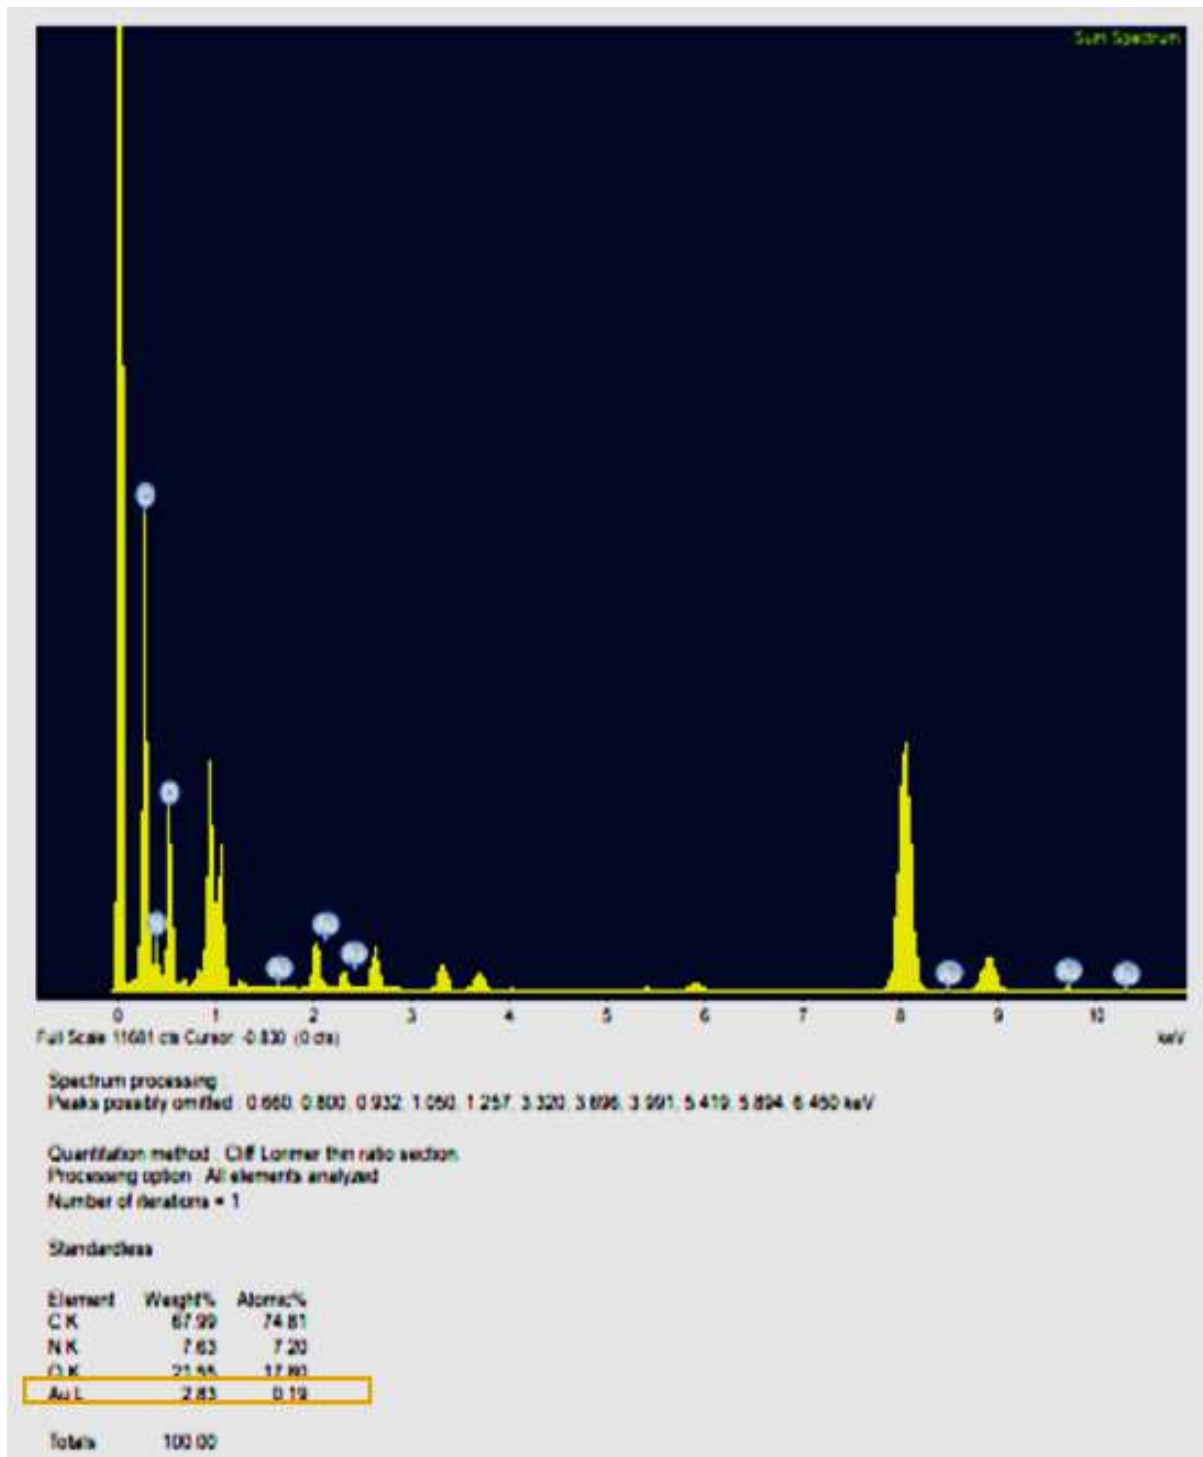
Energy dispersive X-ray analysis. Results of EDX analysis of progeny bacteria grown after 1st sub-culture of Lac_AuNC.
